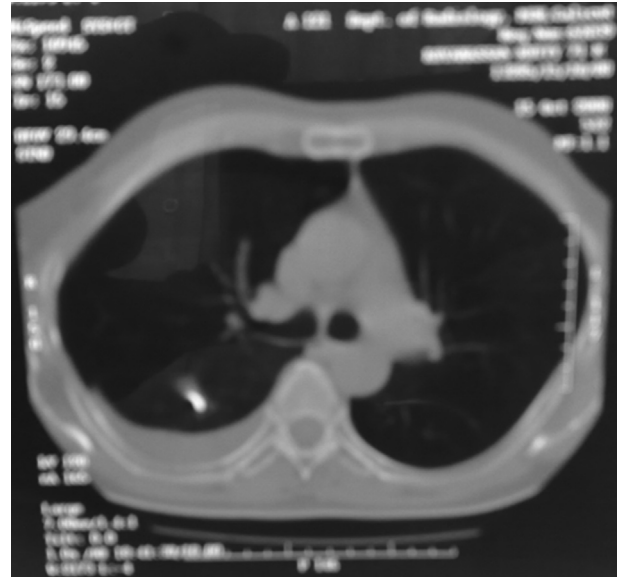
Computed tomography of the chest showing migrated K-wire extending from the inner cortex of right second rib to the upper part of right middle lobe with a hydropneumothorax.
